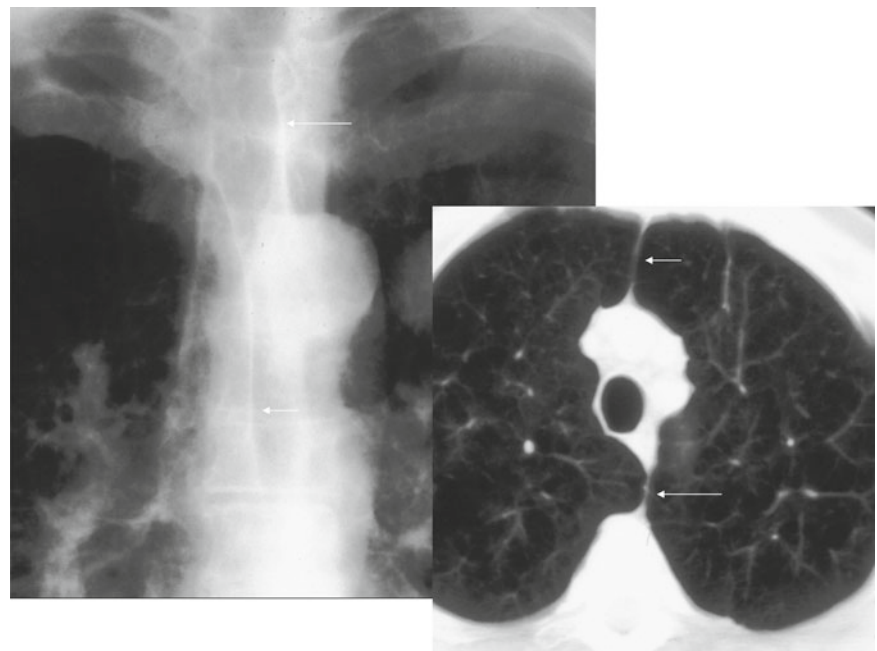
Localized view of the junction lines on a CXR close up and associated CT. The anterior junction line (*short arrows*) is seen anterior to the mediastinum and does not pass up into the neck. The posterior junction line (*long arrows*) is seen posterior to the mediastinum and passes more cranial to the anterior junction lung
